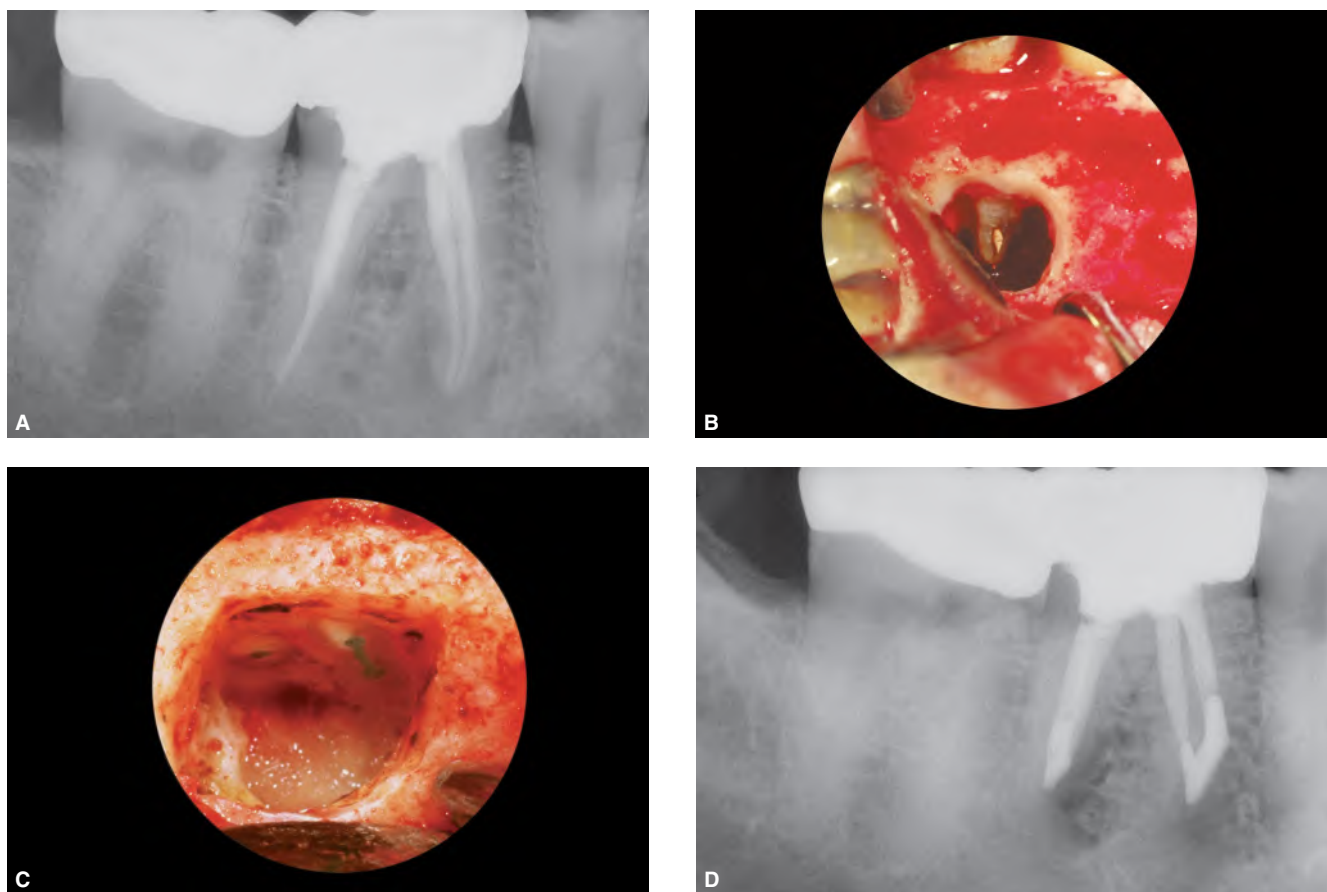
A. Preoperative radiograph of a failing endodontic treatment in a mandibular right first molar. This specific radiographic angle does not reveal the etiology of failure. B. Photograph showing gutta-percha perforating the buccal aspect of the mesial root. C. The apicoectomy and retrograde procedures. Note the management of the isthmus between the MB and ML foramina. D. Post-treatment radiograph showing the surgical efforts.
